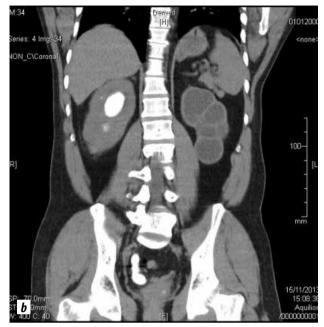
a. Coronal CT sections performed after nephrostomy and attempted retrograde stent insertion. Note the dilated renal pelvis of the right kidney. b. Note how the distal ureter is swollen yet no contrast is able to pass to the empty bladder - demonstrating severe stricture disease
